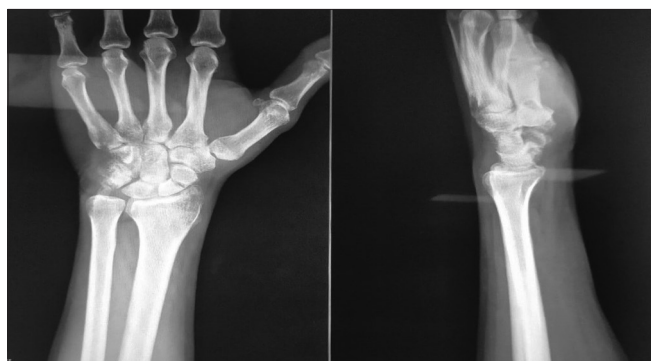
Pre-operative radiograph of Fracture Scaphoid Herbert type B
